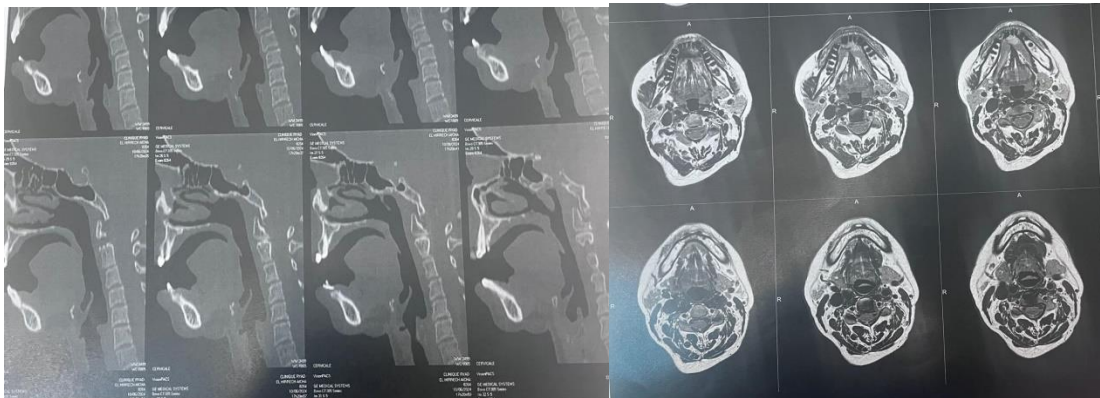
Sagittal CT scan showing a lytic lesion of the floor of the mouth at the lingual surface of the mandibular symphysis (a), axial MRI scan revealing a tumor of the floor of the mouth measuring about 2.5×2.0 cm, infiltrating the cancellous bone of the mandible.
